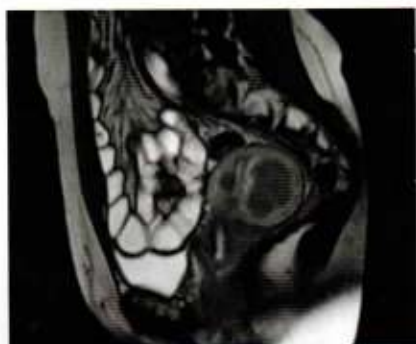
Pre-embolization MRI.
